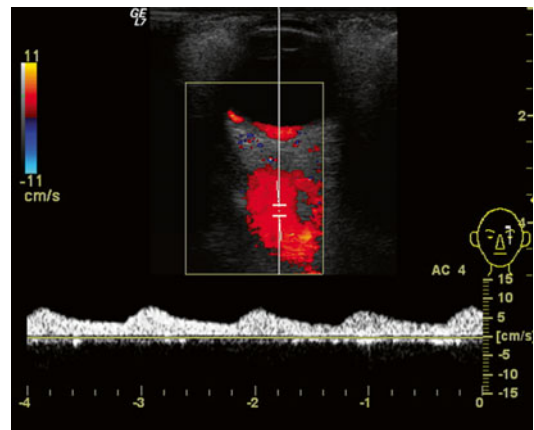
Color Doppler image of a carotid-cavernous fistula. The circulation in the dilated superior ophthalmic vein is reversed and the spectrum is arterIALIZED
